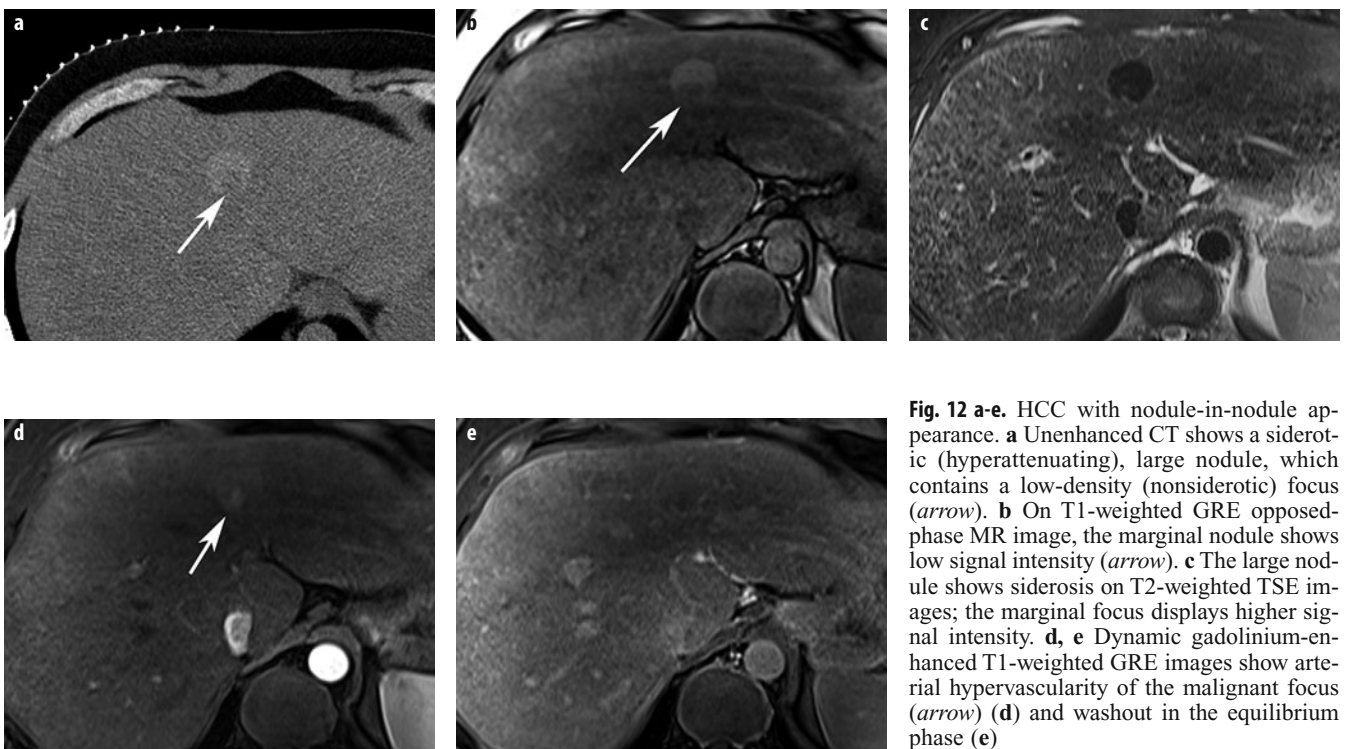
a-e. HCC with nodule-in-nodule appearance. a Unenhanced CT shows a siderotic (hyperattenuating), large nodule, which contains a low-density (nonsiderotic) focus (*arrow*). b On T1-weighted GRE opposed-phase MR image, the marginal nodule shows low signal intensity (*arrow*). c The large nodule shows siderosis on T2-weighted TSE images; the marginal focus displays higher signal intensity. d, e Dynamic gadolinium-enhanced T1-weighted GRE images show arterial hypervascularity of the malignant focus (*arrow*) (d) and washout in the equilibrium phase (e)
